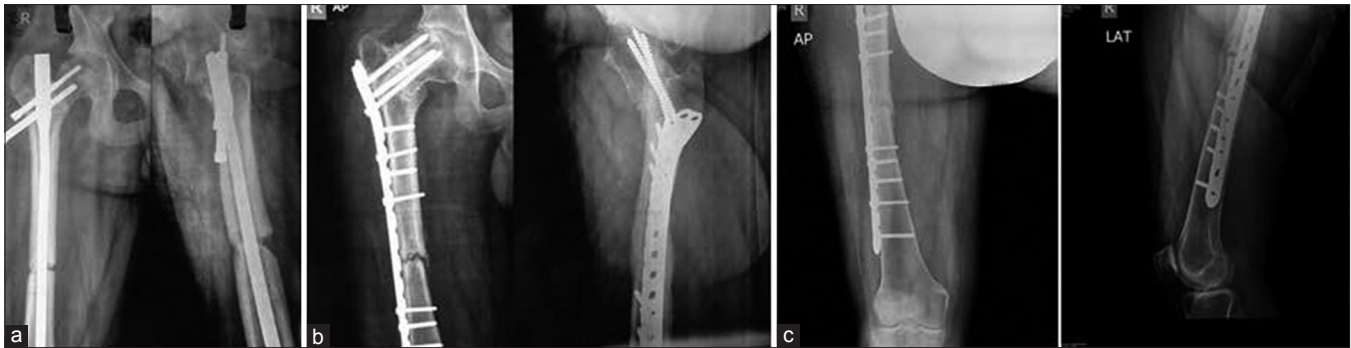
(a) Anteroposterior and lateral radiographs of a 22-year-old man showing nonunion of ipsilateral femoral neck and shaft fracture following four previous surgeries using a dynamic hip screw and a long proximal femoral nail. Due to repeated surgeries, the proximal femoral bone stock was inadequate. (b) After removal of the implant, autologous fibula bone grafting was performed in the femoral neck, followed by fixation with a reverse distal femoral locking compression plate. Radiographs at the 4-month followup show the union of the femoral neck fracture. However, the femoral shaft fracture shows delayed union. (c) Radiographs demonstrating union of the femoral shaft fracture at 3 months after bone grafting
